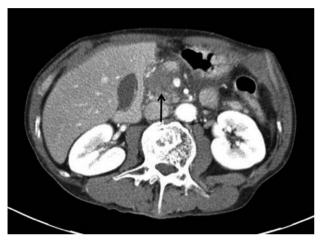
Initial abdominal computed tomography showing a hematoma (black arrow) in the pancreatic head adjacent to the superior mesenteric vein, with a retroperitoneal hematoma.
